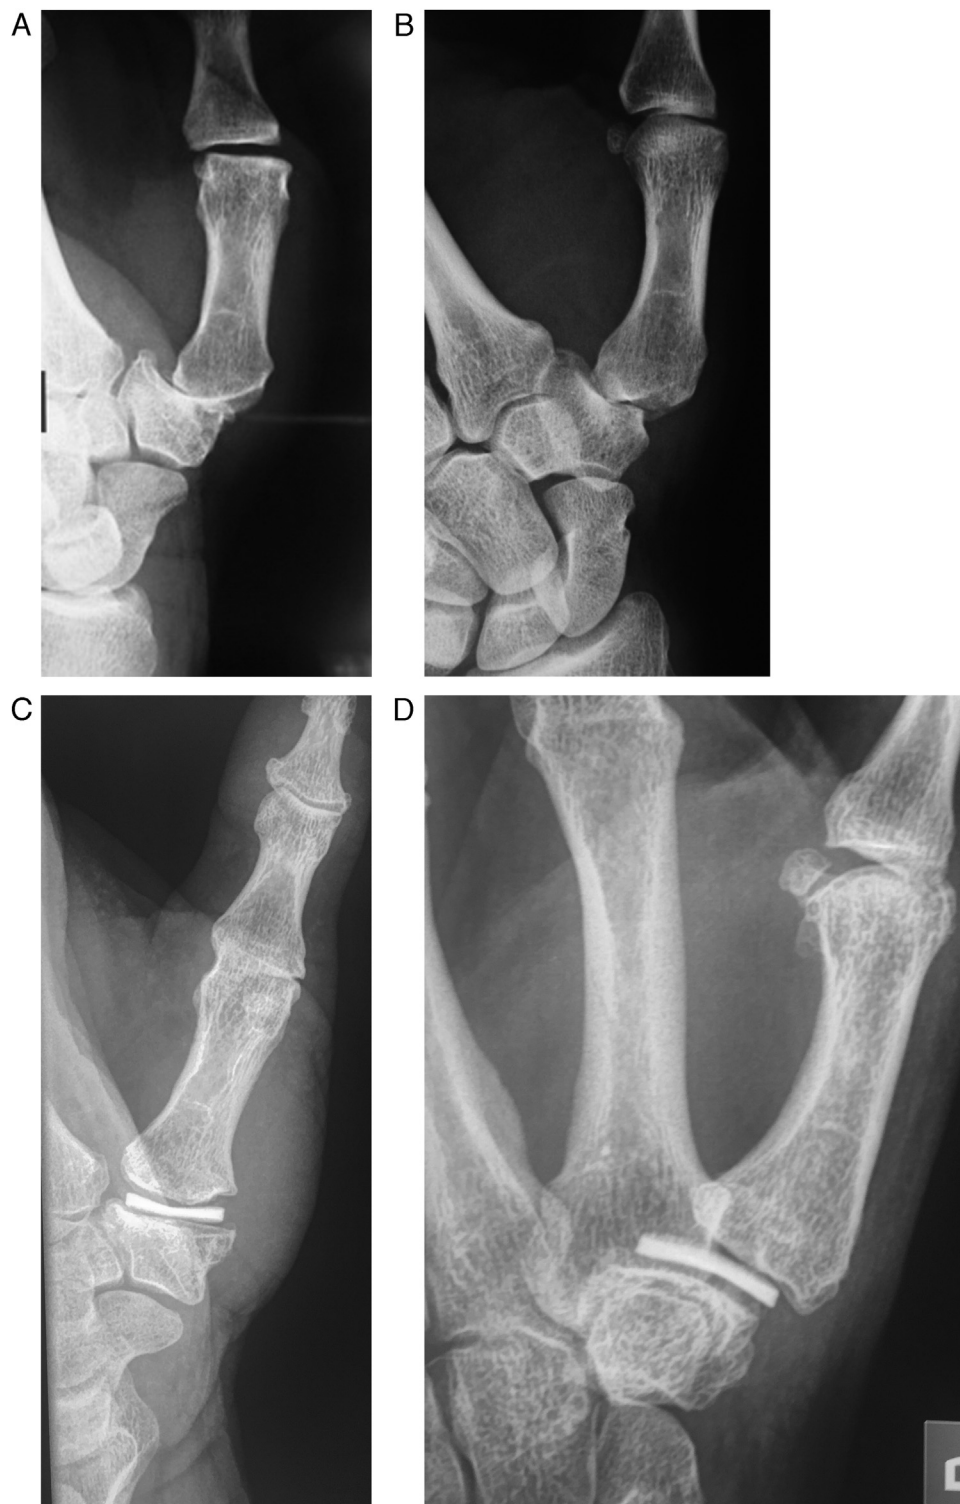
TMC joint OA with metacarpal subluxation on the left (non-dominant) side in a 47-year-old heavy manual laborer (industrial logistics) treated with a Pyrocardan[®] implant. Clinical result after 7 years: Kapandji score = 10/10, pain on VAS = 0/10, PRWE = 0/100, QuickDASH = 0/100, Tip pinch = 10 kg, Key pinch = 12.5 kg, Grip strength = 38 kg. Preoperative AP (A) and lateral (B) radiographic views. Postoperative AP (C) and lateral (D) radiographic views after 7 years.
